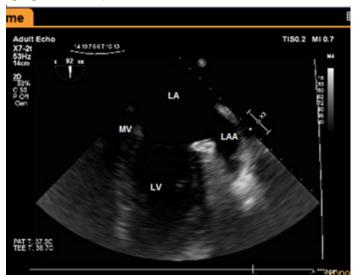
Transesophageal echocardiography. Midesophageal view at 92 degrees. Left atrial appendage without any thrombus.
